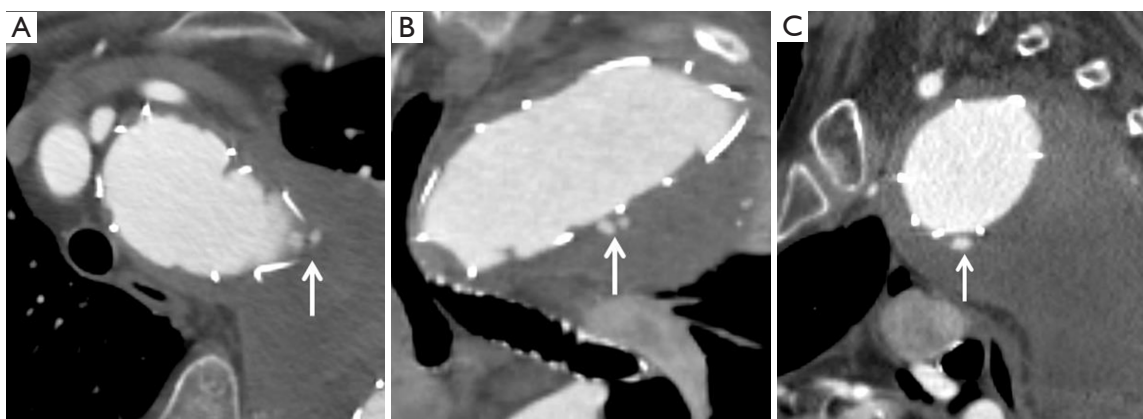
A 78-year-old woman with type III endoleak. (A) Axial CT angiogram shows small contrast material (arrow) outside the stent-graft at level of mid aortic arch; (B) coronal and (C) sagittal reformatted CT images demonstrate contrast material (arrows) outside the stent graft, but still within the aneurysm sac.
